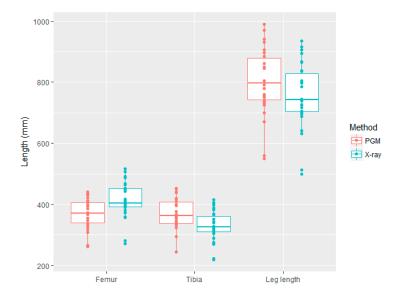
Differences in the median, quartiles, extreme values and outlier subjects for segmental and leg length measured by PGM and X-ray.
